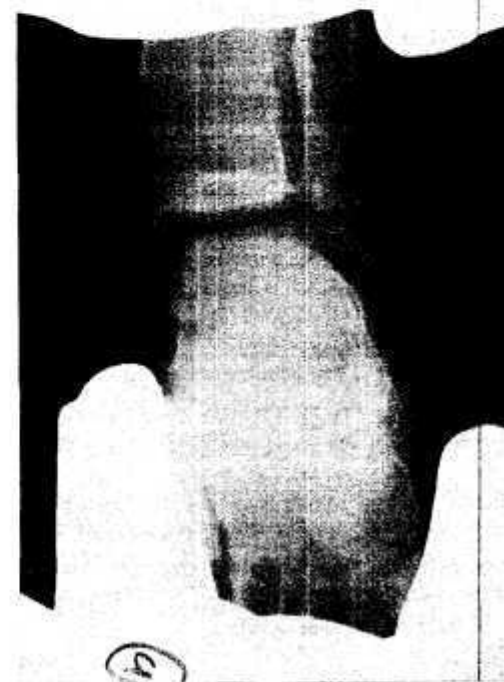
Stress radiograph demonstrating syndesmosis injury and deltoid ligament tear. (Reprinted from Clanton, TO. Athletic injuries to the soft tissues of the foot and ankle. In: Coughlin, MJ, Mann RA, editors. Surgery of the foot and ankle, 7th edition, volume 2. St Louis: Mosby; 1999; with permission.)
